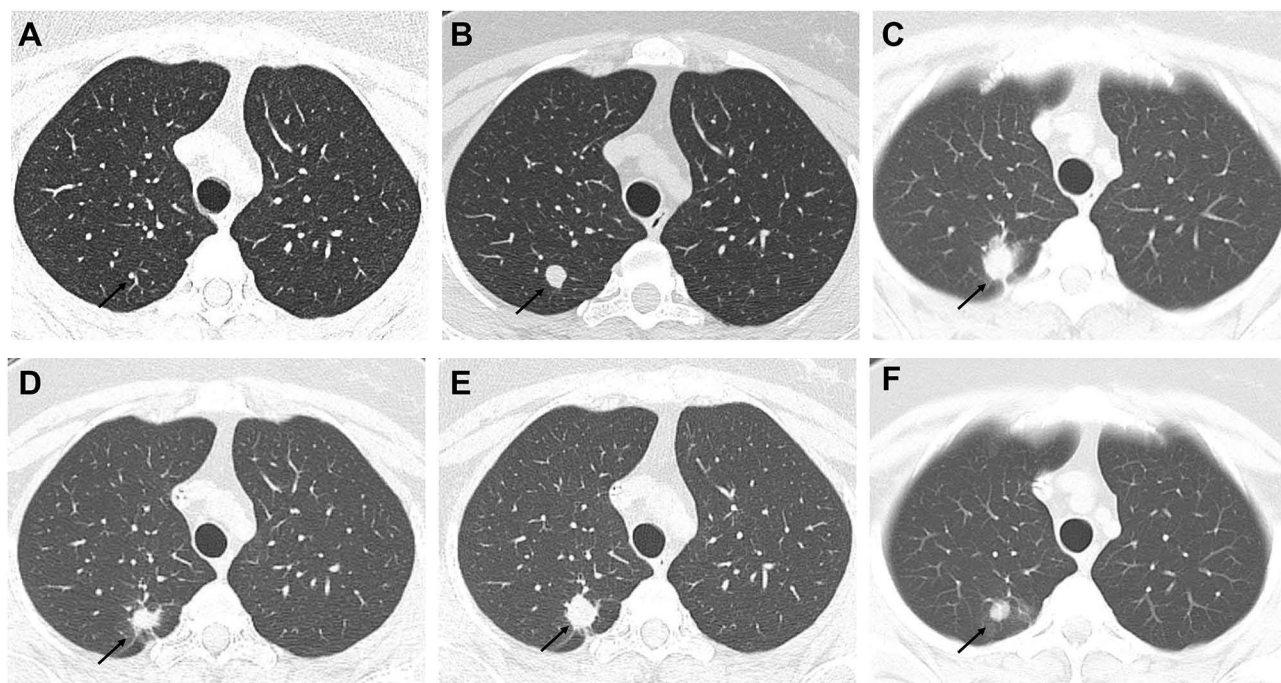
Lung CT images.
